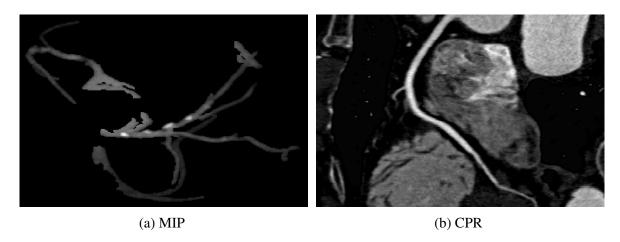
Interpretation of a CTA image for effective diagnosis in clinical practice. (a) Maximum intensity projection (MIP) representing the coronary vasculature and calcified plaques. (b) Curved-planar reformatted (CPR) image representing right coronary artery in a 3D CTA volume.
